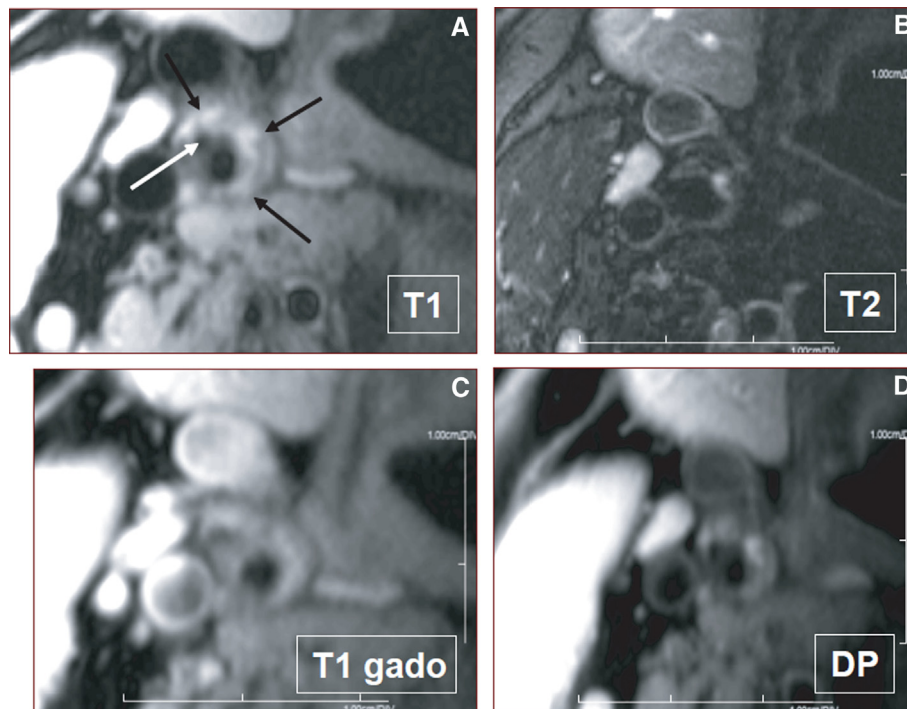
High-resolution cross-sectional magnetic resonance imaging of the right carotid bifurcation of an asymptomatic patient. (A) On T1-weighted acquisition of right internal carotid artery stenosis, the plaque appears heterogeneous. The external carotid artery lumen is observed (white arrow), and both vessel walls consist of heterogeneous signals, which reflect fibrocalcific tissue (black arrows). (B–D) T2-weighted and proton density (DP) images, showing a hyperintense area in the medial internal carotid artery wall, not clearly apparent on T1 pre- and postcontrast (T1 gado) images, which likely represents loose matrix fibrous tissue. There is no significant plaque enhancement after gadolinium injection, which suggests the absence of neovascularization or inflammation. This figure is available in colour online at <http://carjonline.org/>.
